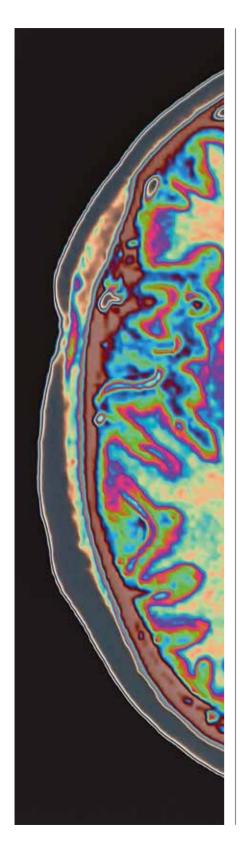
Brain abnormalities identified by the MELD AI algorithm (highlighted in lime green) on MRI scans of children and adults with epilepsy from around the world.
